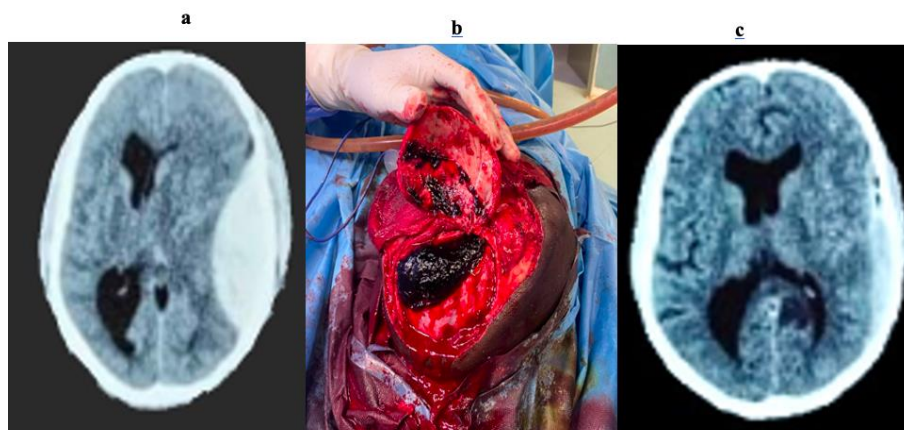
(a): A non-contrast axial CT scan of a patient admitted for head trauma, showing a hyperdense, biconvex lens-shaped image in the left parietal lobe, suggestive of an external hematoma (EH). (b): An intraoperative image of the EH in the same patient. (c): A non-contrast axial CT scan of the same patient, showing near-complete resolution of the hematoma.
